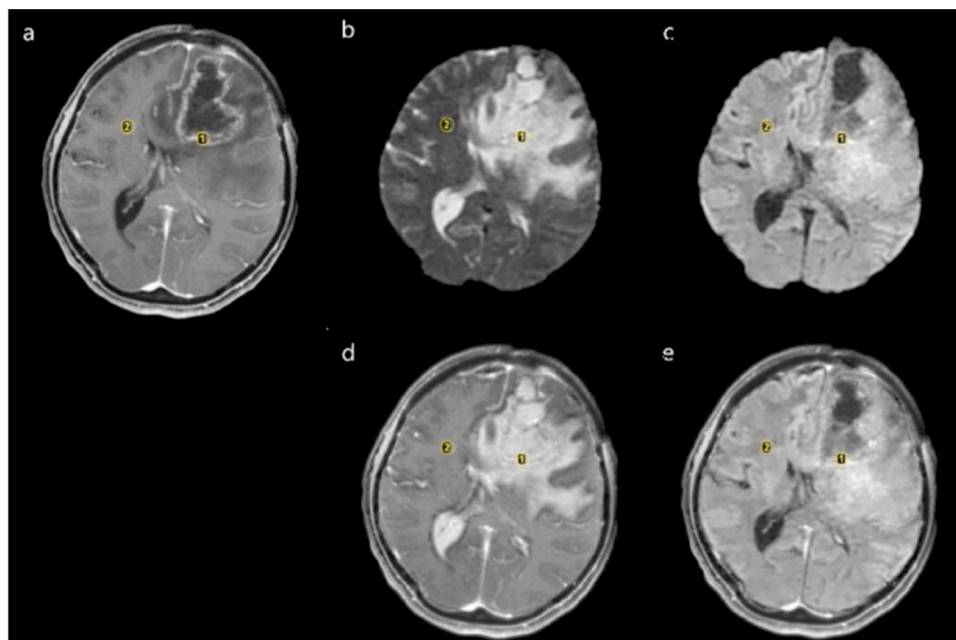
image of a 54 year-old woman with grade IV glioma. (a) axial post-contrast T1-weighted (T1Gd) (b) diffusion-weighted image (DWI) with b-value 50 (b-50) (c) DWI with b-value 1000 (b-1000). (d) fused image of T1Gd + b50 with LRD fusion algorithm. (e) fused image of T1Gd + b1000 with LRD fusion algorithm. In all images ROI 1 is enhancement region (ER) and ROI 2 is white matter region (WM).
